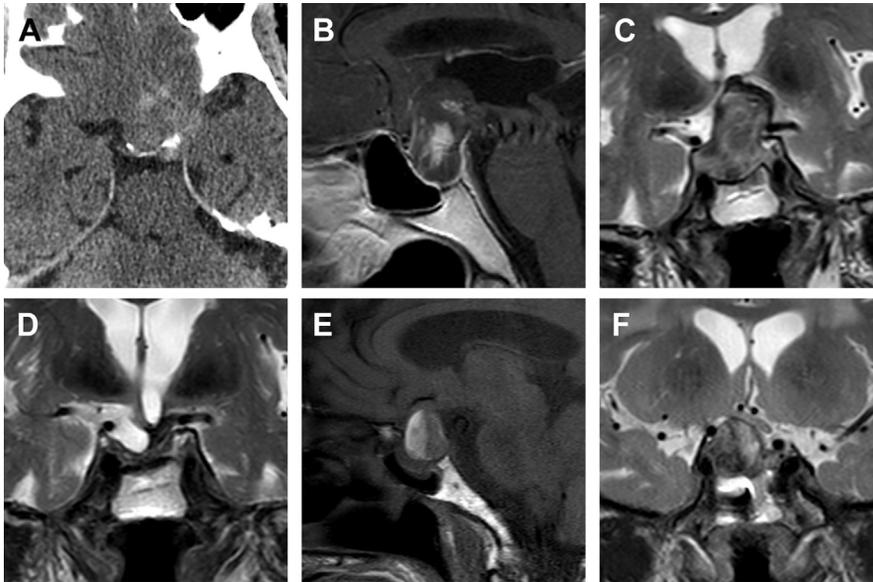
Pituitary apoplexy. (A) An 86-year-old man with acute onset headache. Noncontrast CT shows sellar enlargement with a hyperdense lesion and adjacent subarachnoid hemorrhage. (B) Sagittal T1WI and (C) coronal T2WI show a sellar mass bulging upward into the suprasellar cistern with heterogeneous internal signal due to diffuse intralésion hemorrhage. (D) Following transsphenoidal decompression, there is decreased mass effect, chronic hemosiderin, and tethering of the optic chiasm. (E, F) A 74-year-old man with acute endocrine collapse. Sagittal T1WI and coronal T2WI show an enlarged pituitary with heterogeneous signal intensity and a hemorrhagic fluid level.
